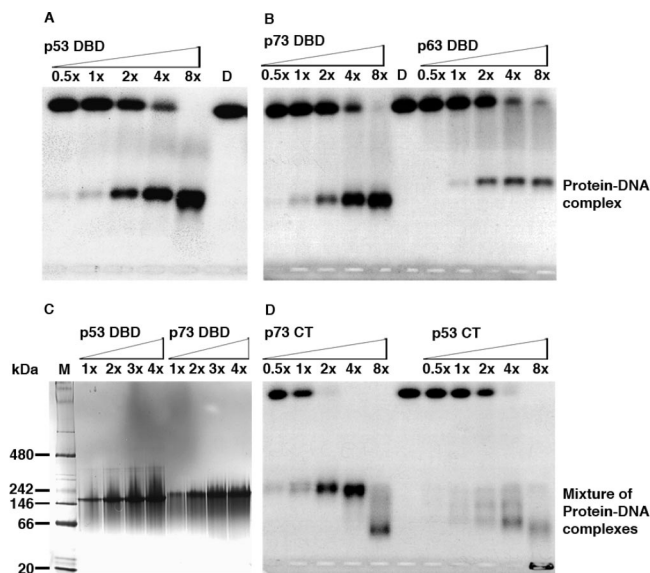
Electrophoretic mobility shift assays (EMSA) of the p53 family of proteins. Binding to *gadd45* dsDNA was used as a model system. Titration experiments were carried out for (A) p53 DBD, (B) p73 DBD and p63 DBD, and (D) p73 CT and p53 CT constructs at a DNA concentration of  $1 \times 10^{-8}$  M and increasing concentrations of protein (protein:DNA ratios are indicated above each lane, D indicates DNA alone). The analyses were performed using 0.7% agarose gels. (C) Titration experiments were carried out for p53 DBD and p73 DBD constructs as described above but using a DNA concentration of 15  $\mu$ M and increasing protein concentrations (as indicated above each lane, M indicates the Native Mark marker). The analyses were performed on a 4–16% preprepared Native PAGE gel (Invitrogen).
